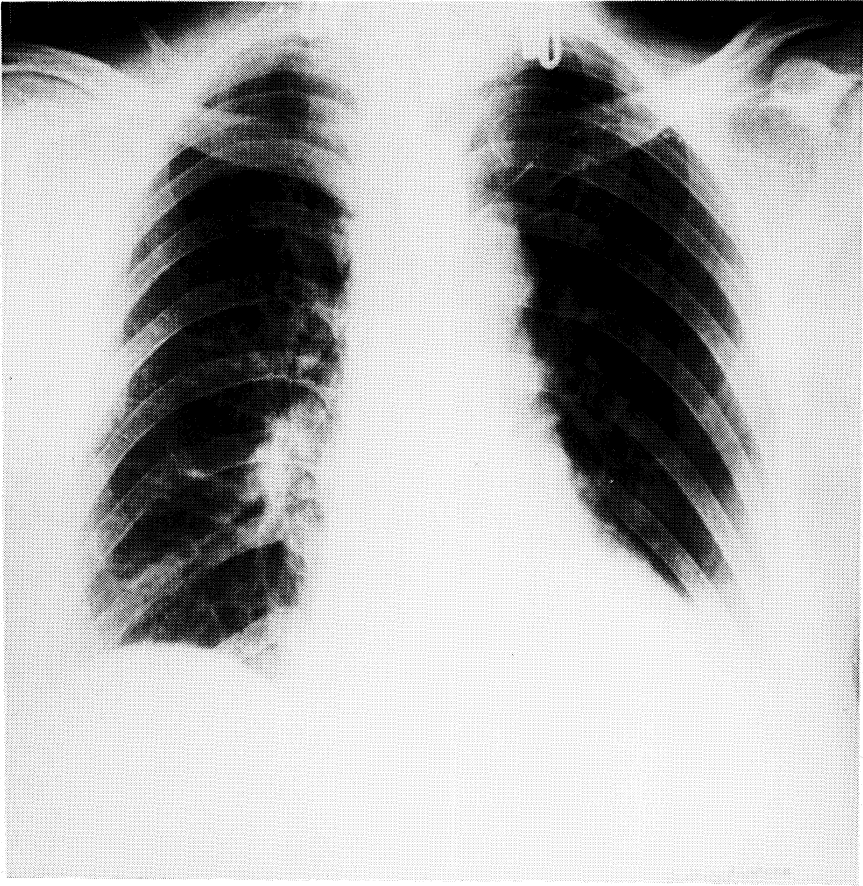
Chest x-ray of a 54-year-old woman with myocardial re-infarction and massive lung congestion during volume-controlled ventilation with an I/E ratio of 1:2.
